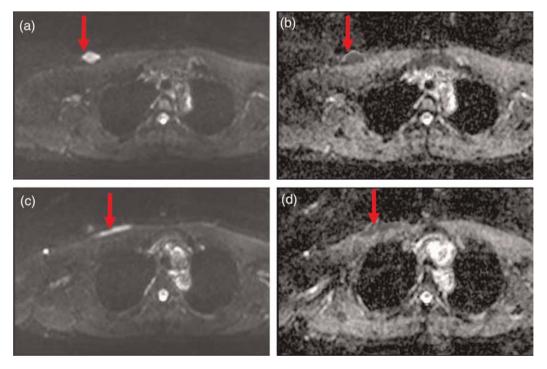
Both mass lesions exhibited high signals on DWI (a, c) and low signals on ADC maps (b, d)
